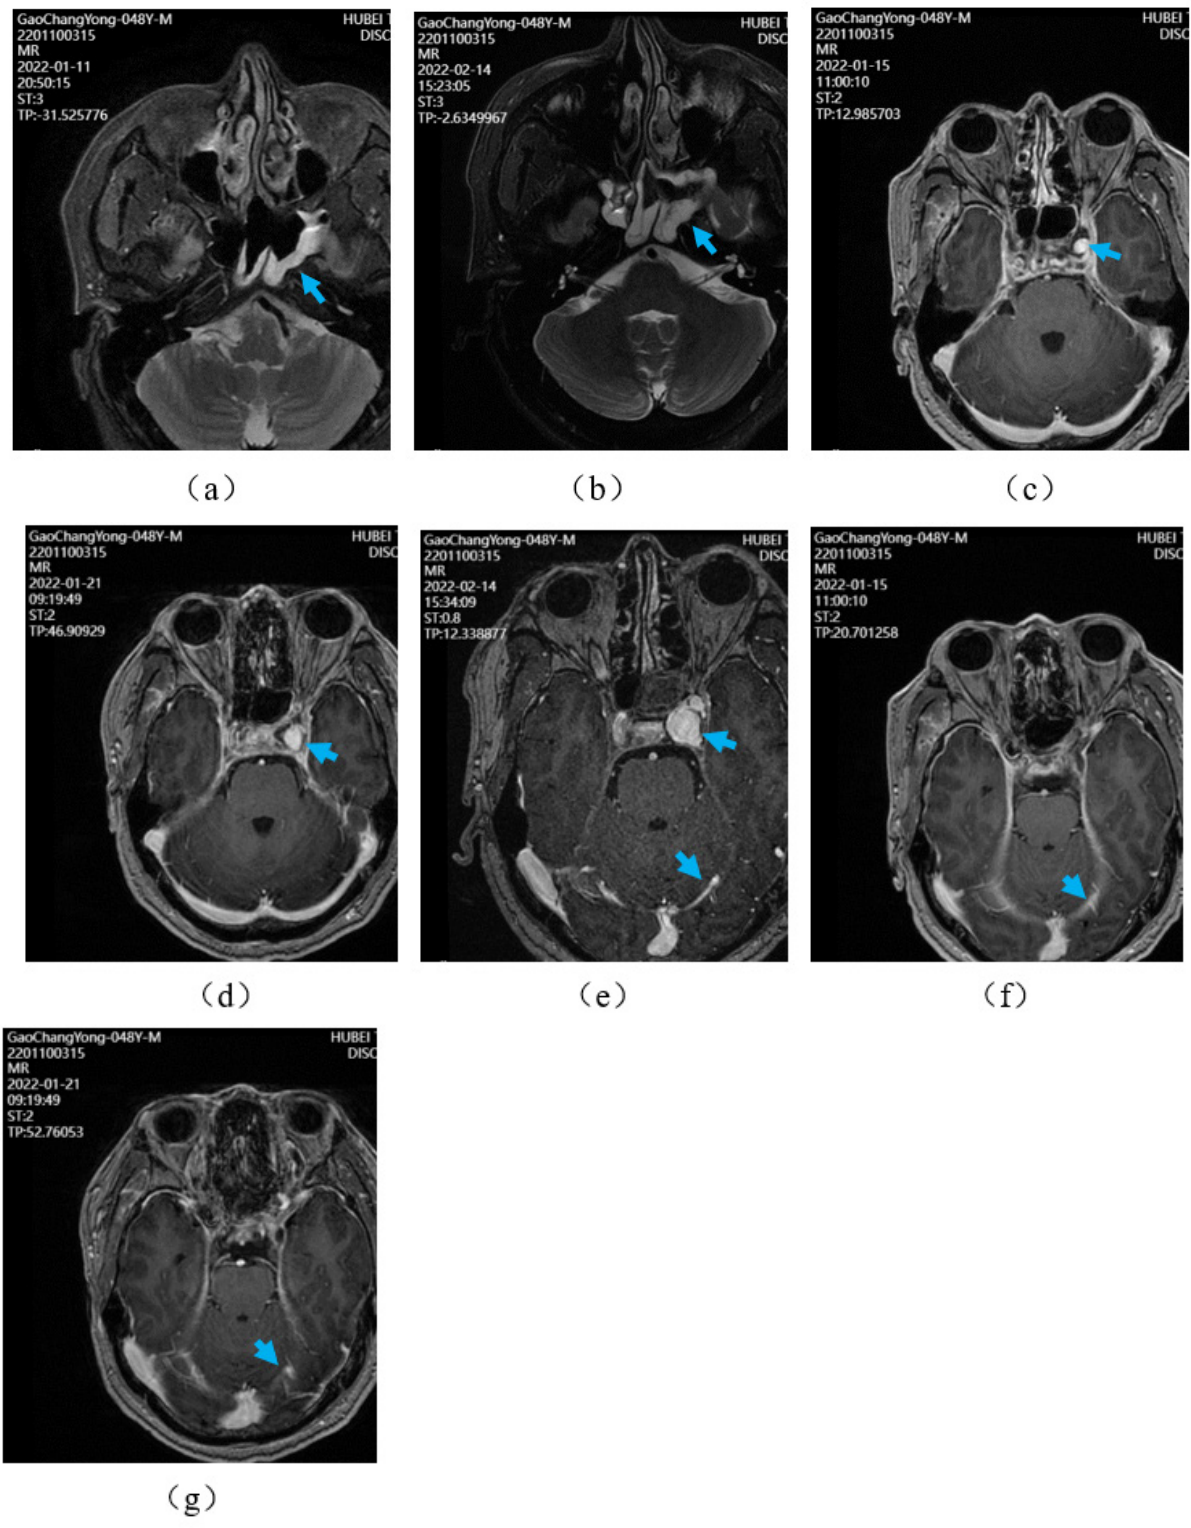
MRI of sphenoid sinus, sphenoid wing and cavernous sinus.
